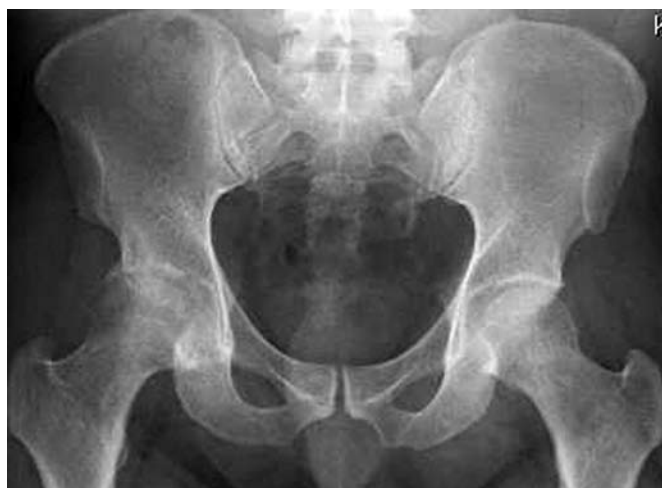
Anteroposterior radiograph of the pelvis.
